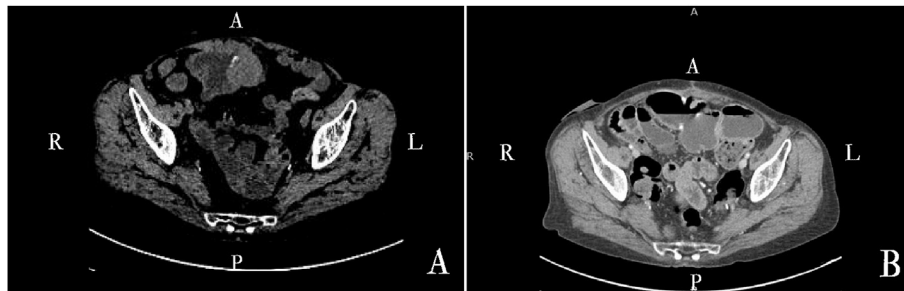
Abdominal CT A. CT of the abdomen without contrast. A large 3.6×3.3 cm mass seen within the Indiana pouch. B. CT of the abdomen with IV contrast at four-month follow-up. Status post cystectomy and partial right hemicolectomy with right lower quadrant ileal conduit. No evidence of metastatic disease.
